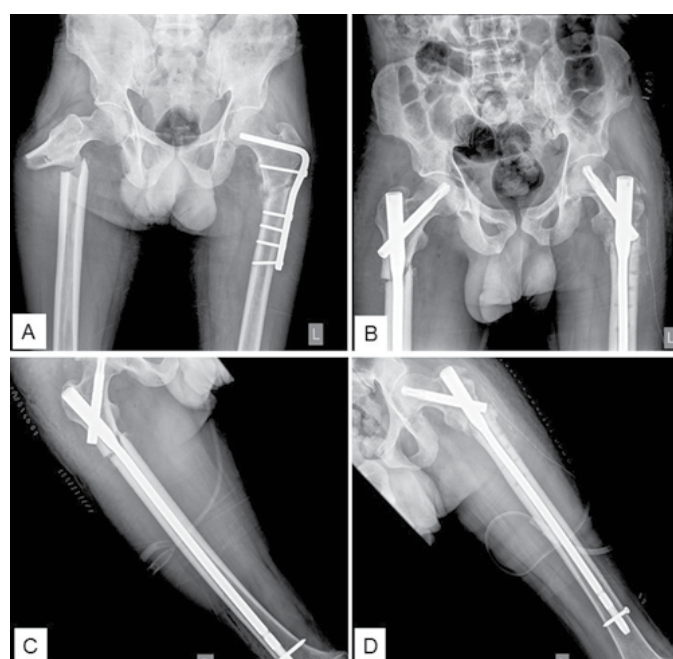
(A) Radiograph taken at the time of second fall corresponding to one year follow-up of first surgery; (B–D) Immediate postoperative radiograph after bilateral fixation with proximal femoral nail.
